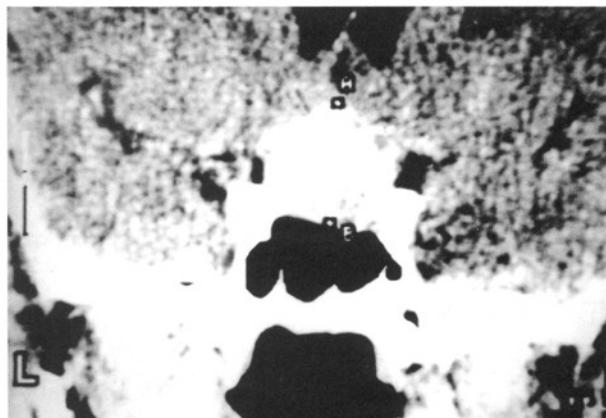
The preoperative CT scan showed a mass in the pituitary fossa.
